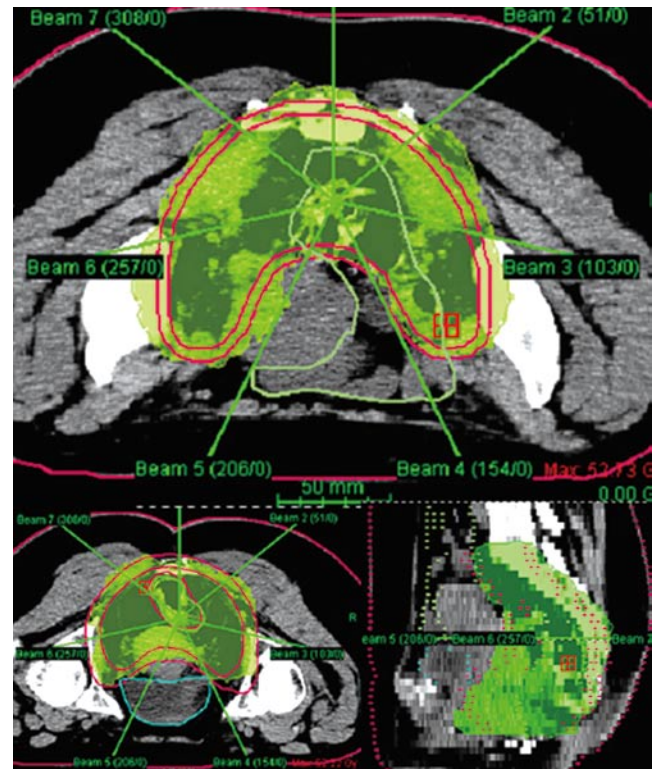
Axial and sagittal CT scan images with dose distributions. The 45 Gy isodose surface (green) encompass the GTV and PTV.
